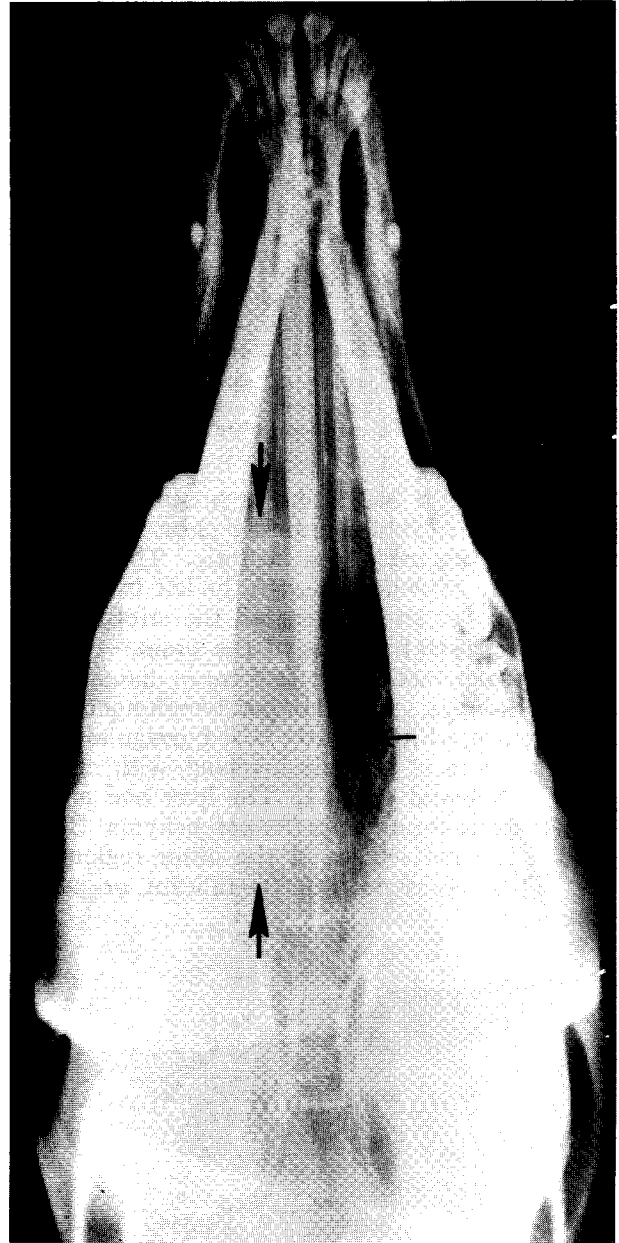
Ventrordorsal radiograph of Eld's deer skull, showing dense mass occupying left caudal nasal passage (arrows), with destruction of ethmoturbinates and erosion and displacement of perpendicular plate of palatine bone.
